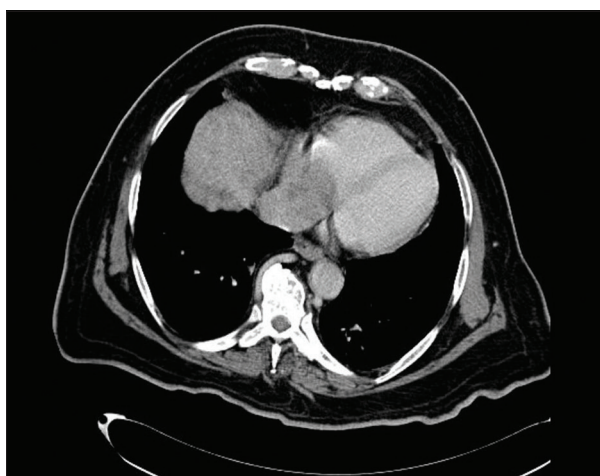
This is an axial plane of Computed tomography scan abdomen that showed hepatoma at segments 6 and 7 invading the right hepatic vein as well as confluence of the inferior vena cava extending into the right atrium of the heart with small ascites with no splenomegaly or other metastasis
